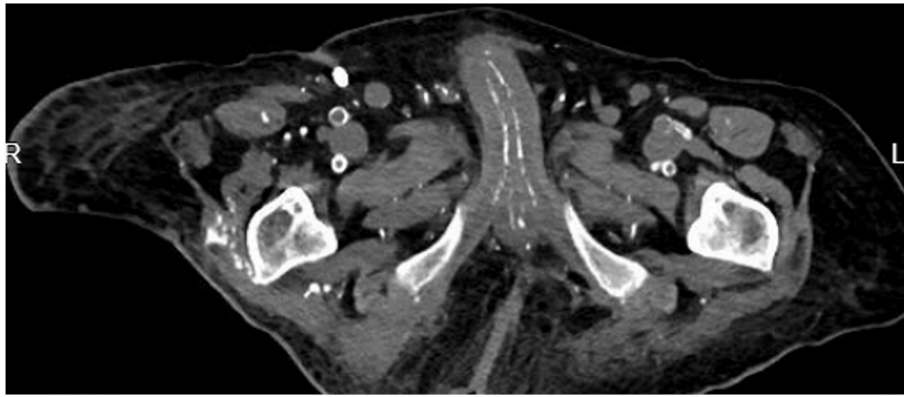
CT ilio-femoral angio showing Extensive calcification of the small and medium vessels supplying the penis.
